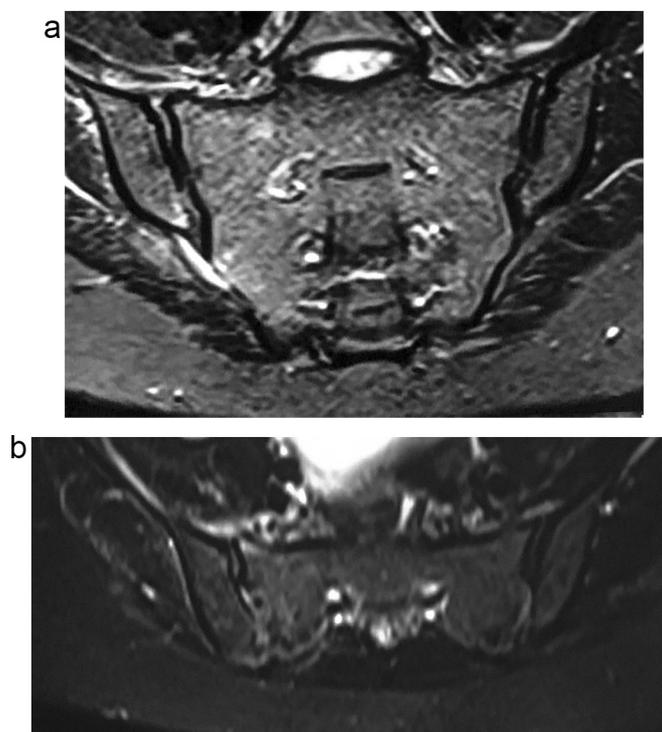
MRI of sacrum and both SI joints at initial presentation. (A) Coronal T2 image showing mild erosions, effusion, and minimal fluid collection at the inferior region of the right SI joint; (B) axial T1 fat suppression image.
